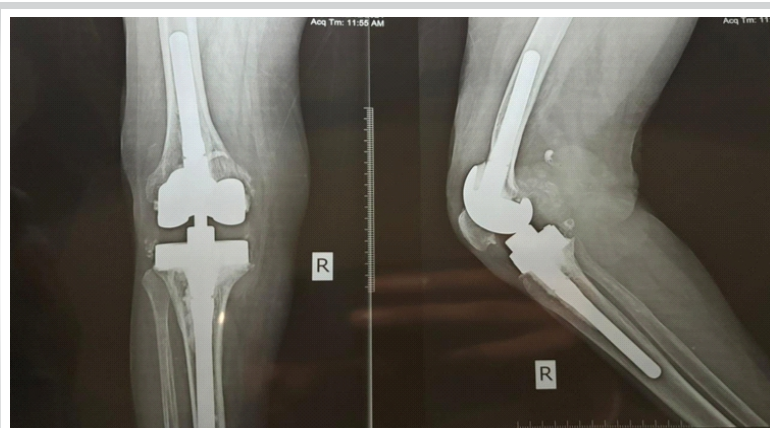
One-year follow-up radiographs of the right knee showing a well-positioned prosthesis with no evidence of loosening or osteolysis.
